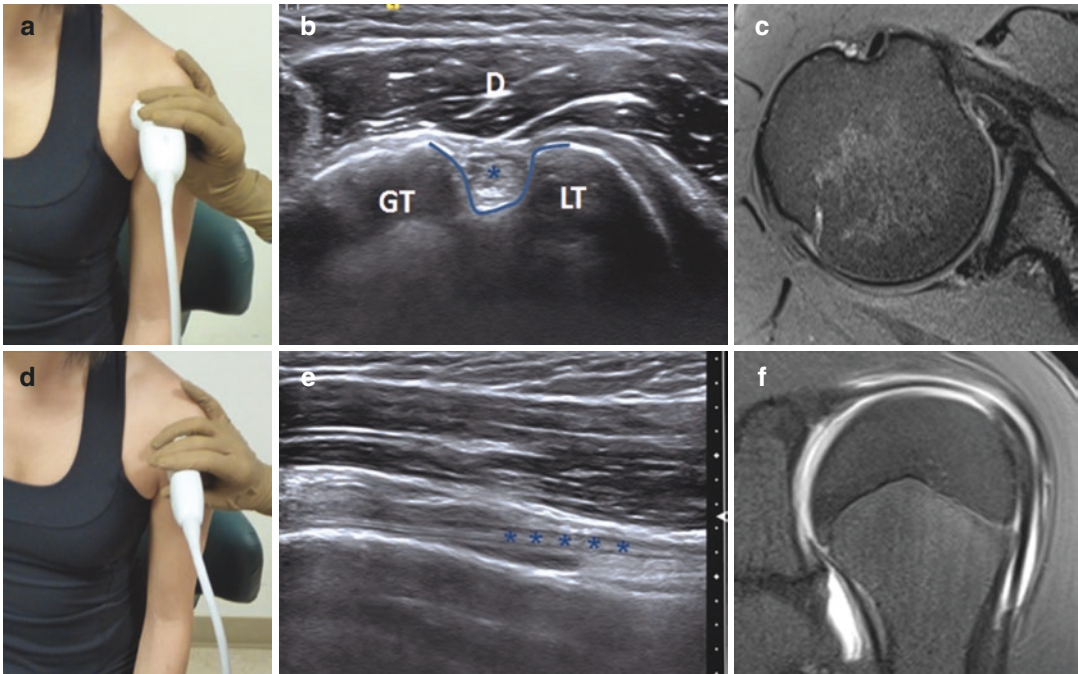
Biceps tendon—short-axis patient positioning (a); short-axis sonographic image (b); MR correlate of short axis (c); long-axis patient positioning (d); long-axis
